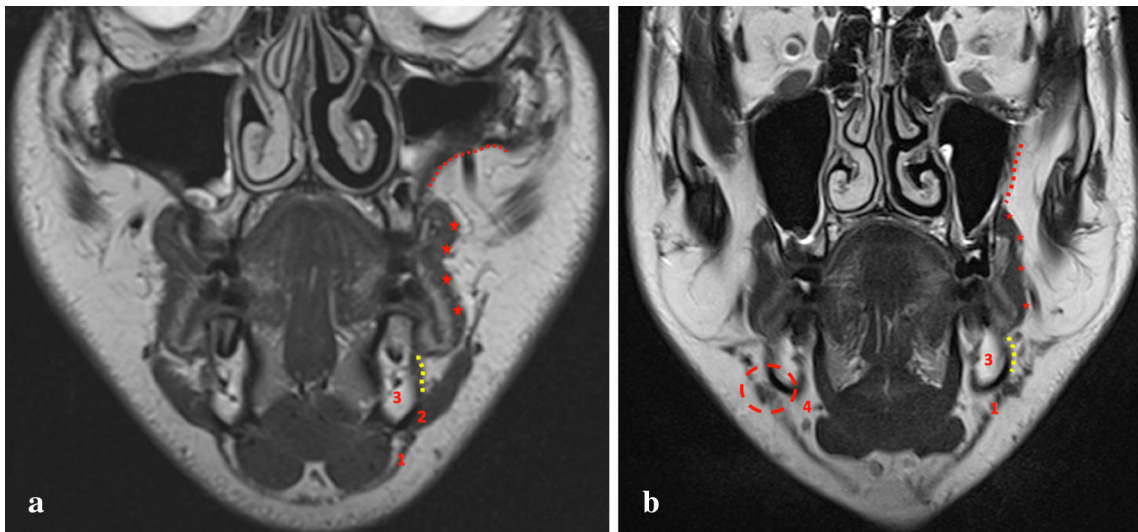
a, b Coronal slices of T2-weighted MRI at the level of the bicuspids (a) and molar teeth (b), showing the medial limit of the BC constituted by the buccinator muscle (*stars*) and the external bone plate of both the maxilla (*red dotted line*) and the mandible (*yellow dotted line*). The images also show the attachment of the depressor
